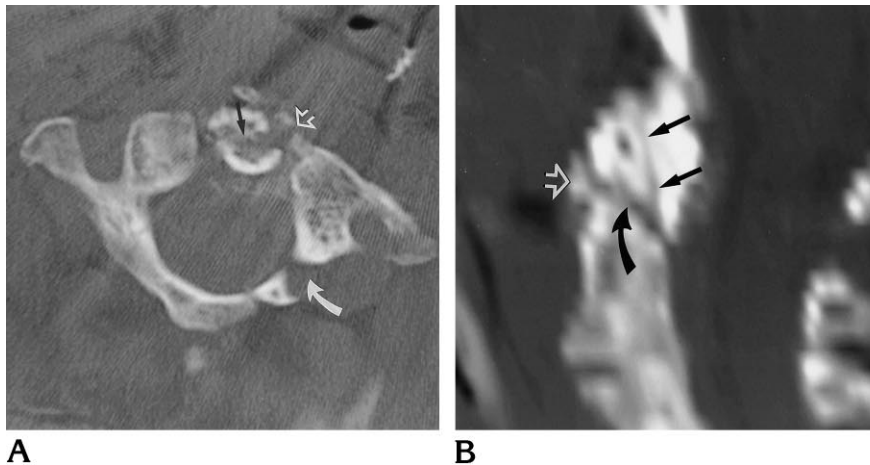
A, Axial CT scan shows vertical fracture through dens (closed arrow) with gap between fracture fragments. Note fractures involving anterior (open arrow) and posterior (curved arrow) arches on left side of C-1, compatible with a unilateral Jefferson-type injury.
